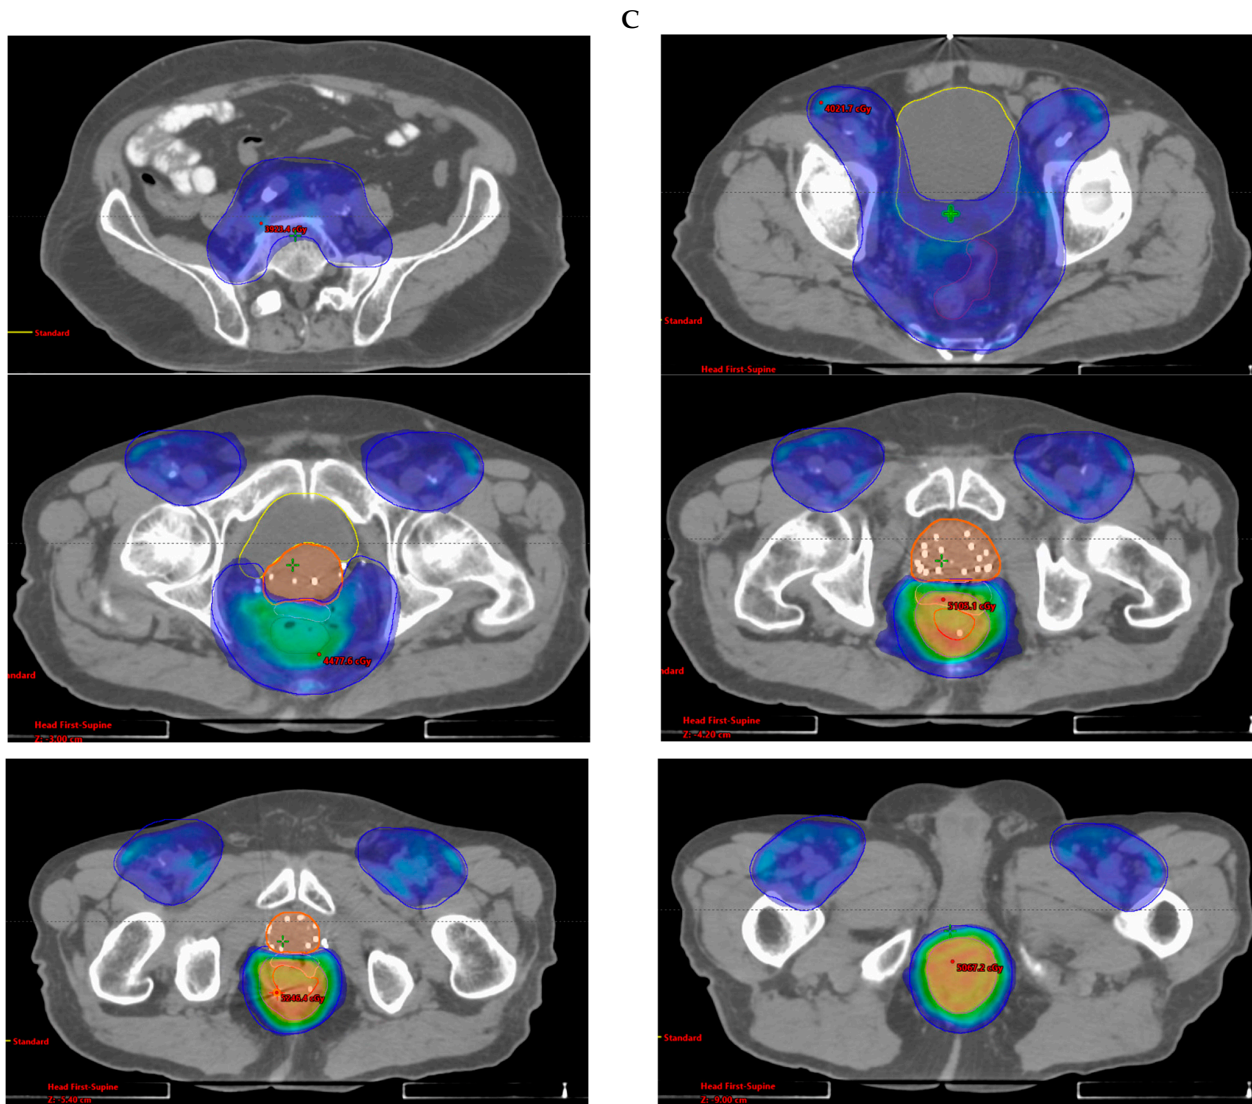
(A) Pretreatment PET/CT images demonstrating a hypermetabolic anal mass. (B) Most recent post-treatment PET/CT images demonstrating post-treatment nonspecific anal hypermetabolism without evidence of disease.
